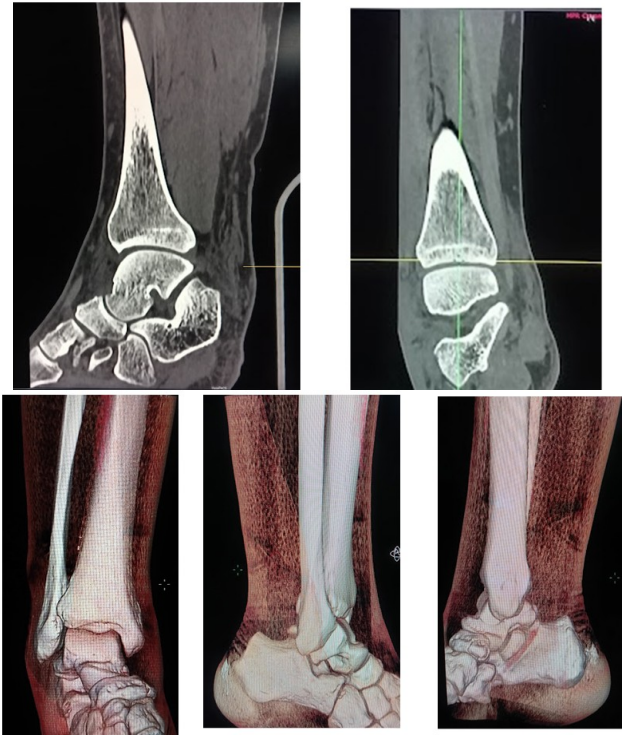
Post reduction CT scan of the ankle
